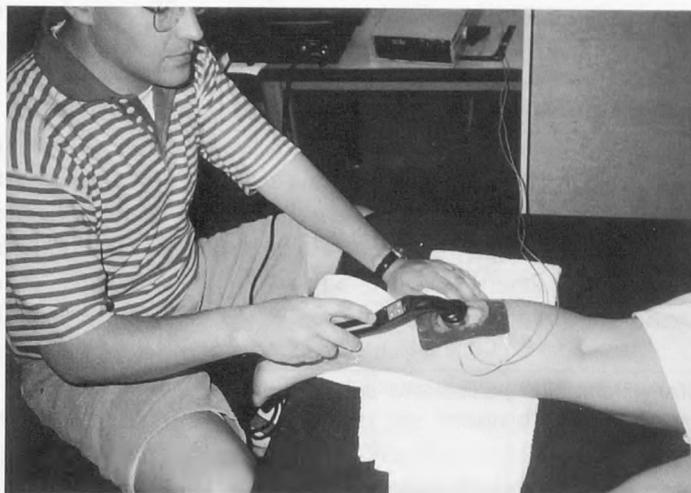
The treatment in progress. Temperature probes were inserted at 3 cm and 5 cm. The template was two times the effective radiating area of the ultrasound transducer head, thus ensuring that all treatments were the same size.
